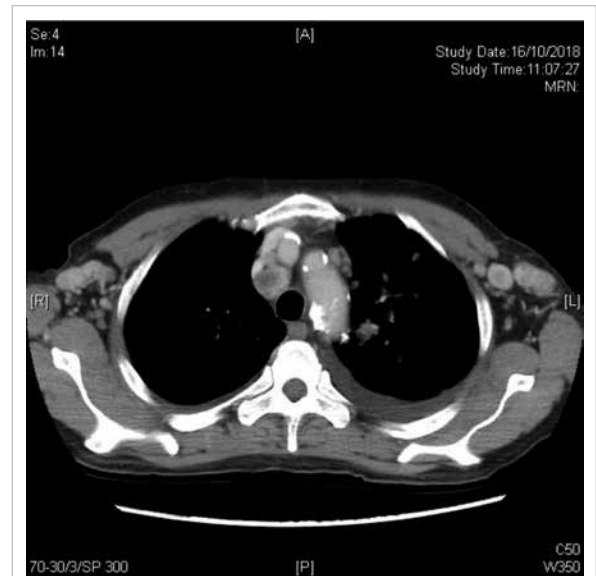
Computed tomography image of thorax showing diffuse mediastinal lymphadenopathy
